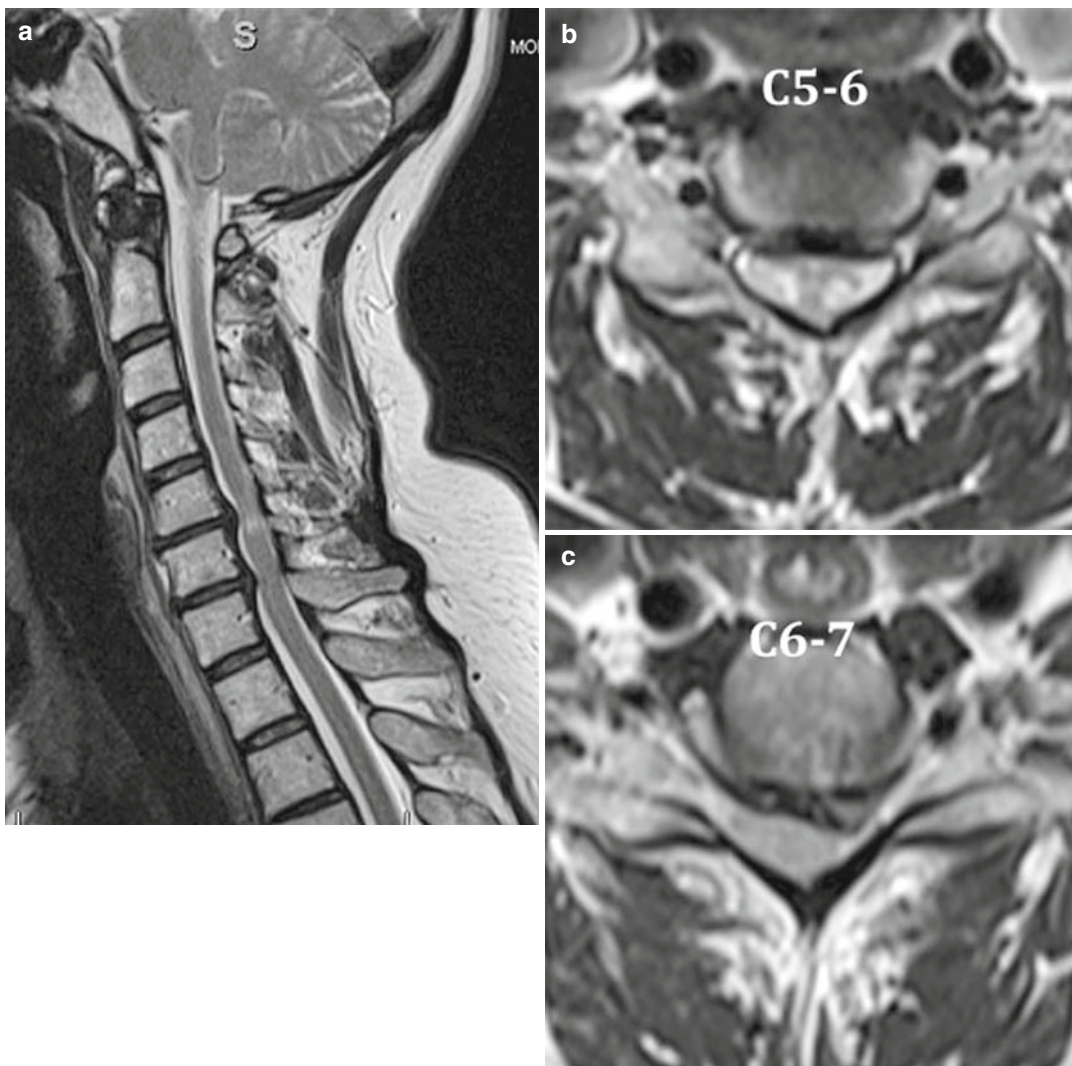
(a) Sagittal and (b, c) axial T2-weighted MRI demonstrates spinal stenosis and cord compression at C5–6 and C6–7. Signal change is visualized within the substance of the spinal cord between C5–6 and C6–7
